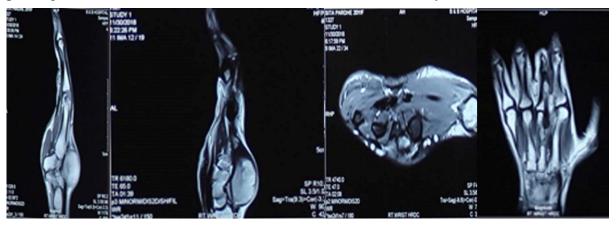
T1W and T2W MRI shows well circumscribed, oval shaped lesion in dorsal aspect of right hand with linear flow void within, encasing the extensor digitorum tendon as described likely benign lesion
